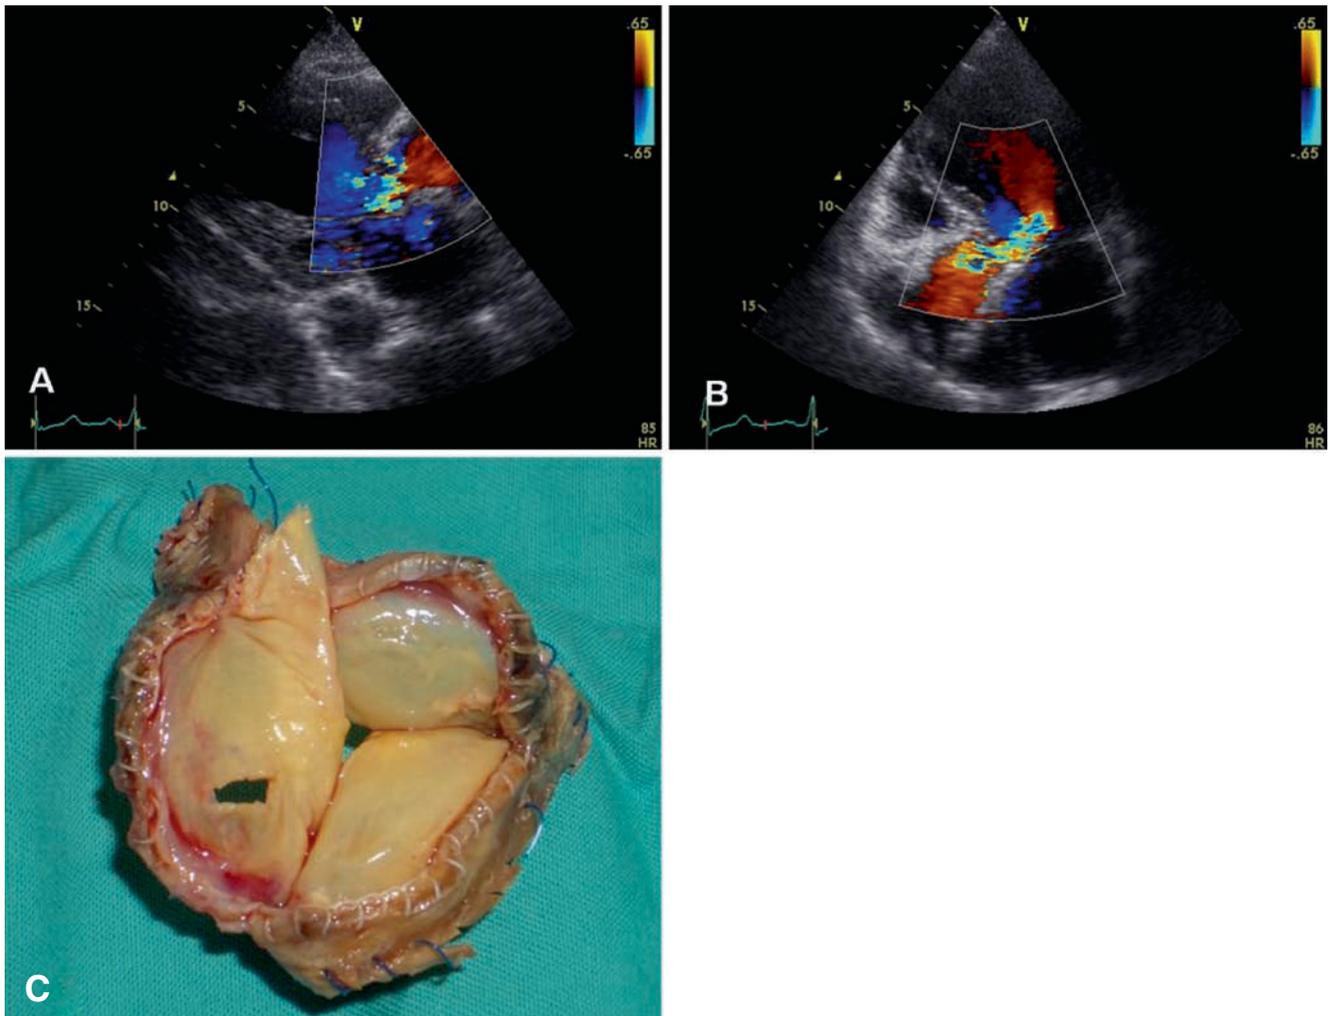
Transthoracic colour Doppler echocardiography demonstrating severe regurgitation of a Cryolife O'Brien bioprosthesis from parasternal (a) and apical approach (b). The explanted valve (c) showed a tear
